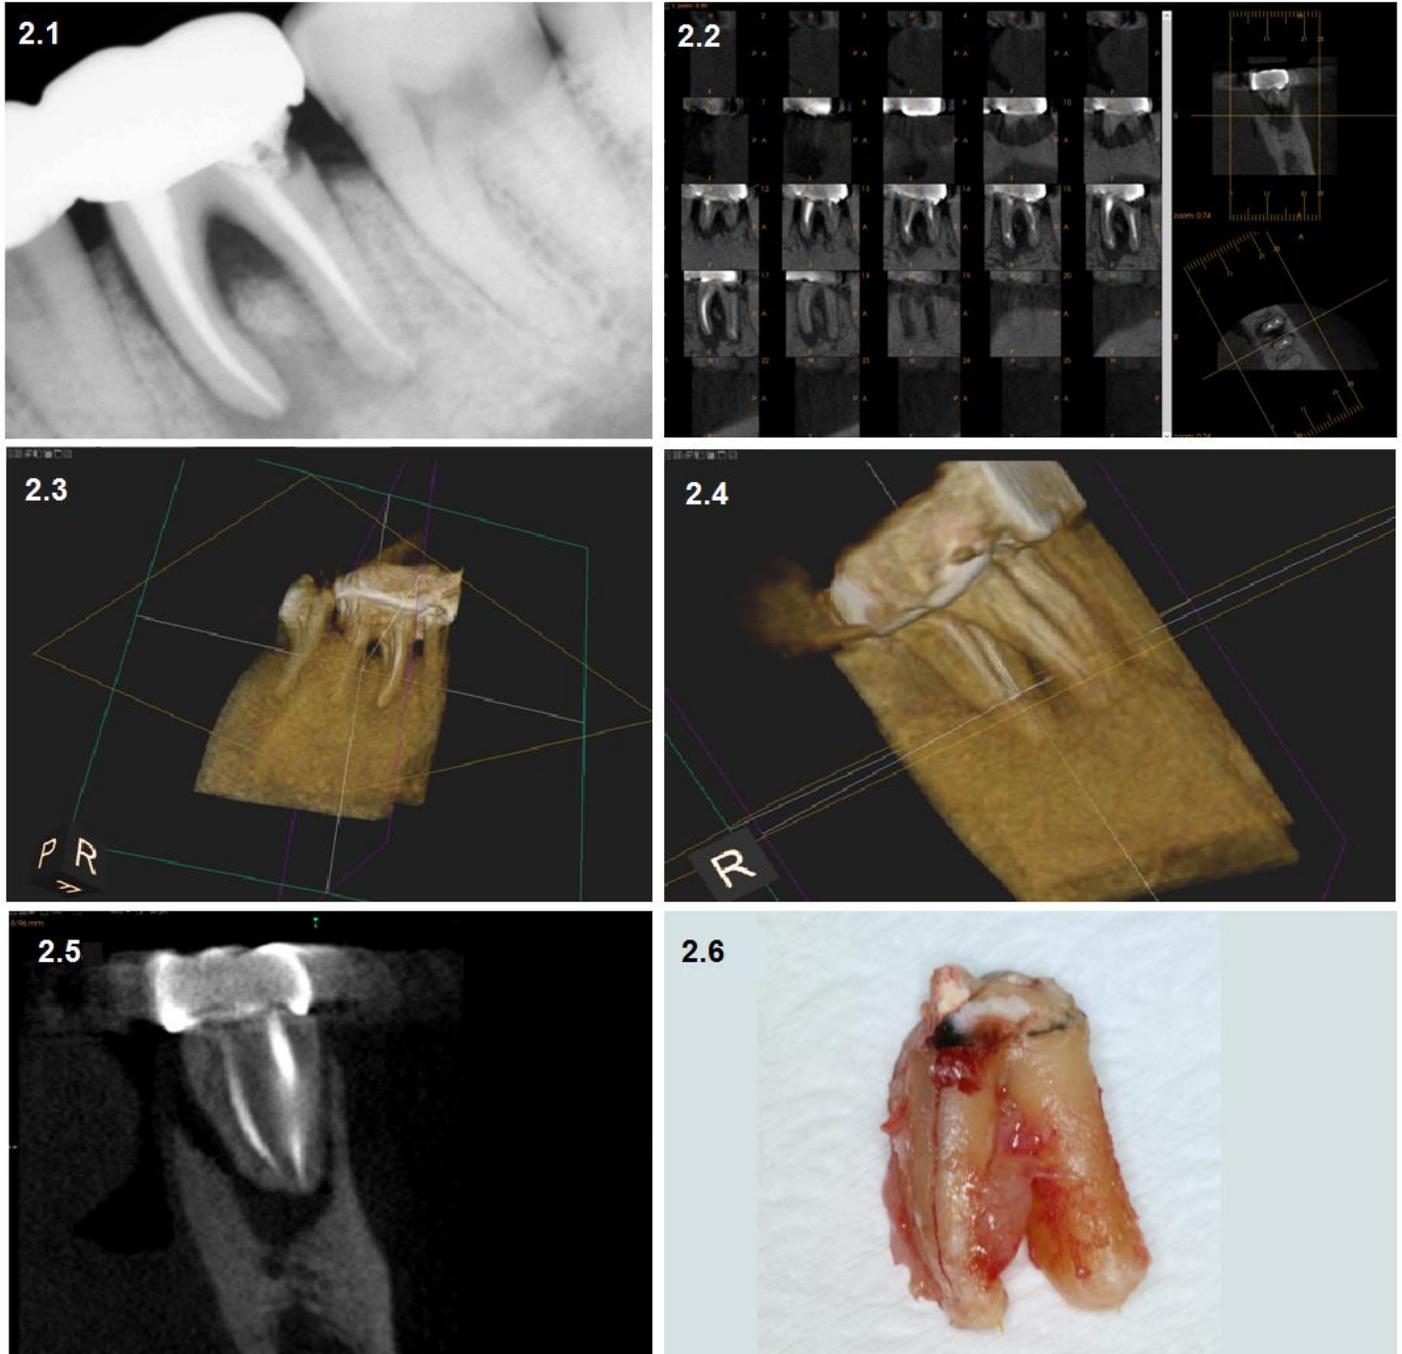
2.1. Diagnostic radiograph; Fig: 2.2. CBCT Images showing sagittal / axial sections and fracture on mesial root; Fig: 2.3. and 2.4. CBCT Images showing oblique sections and fracture on mesial root; Fig: 2.5. CBCT Images showing oblique section and fracture on mesial root; Fig: 2.6. Fracture evident after extraction
